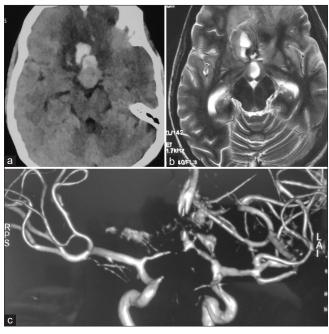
(a) Non-contrast computed topography head suggests hemorrhage in the pituitary gland and interhemispheric fissure with hypodensities in the bilateral medial frontal lobe suggesting infarct; (b) T2 axial MRI suggests a hyperintense lesion in the isointense pituitary gland and hyperintensity in the medial frontal lobe with bilateral loss of sulci and gyri pattern suggestive of the infarct; (c) MR arteriography suggests an aneurysm at the left A1-Acom junction with no visualization of proximal and distal anterior cerebral artery suggestive of diffuse spasm. RPS: Right posterosuperior; LAI: Left Anteroinferior.
